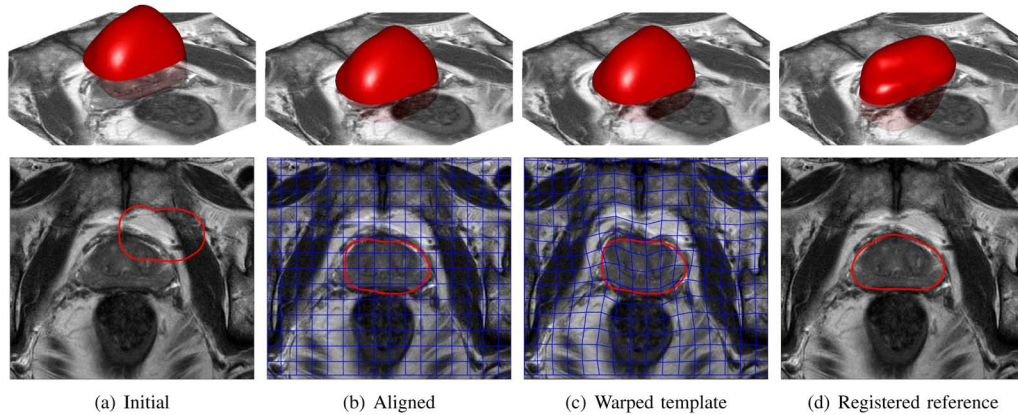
Registration process. (a) The initial *ex vivo* reference model (red) is overlaid on a slice of the *in vivo* T2-weighted template image. (b) Translated, rotated and scaled model after using the model-based alignment. (c) Warped template after using the proposed model-based elastic registration. (d) Registered model after applying the inverse map. A 3-D view (top row) of the model, and a 2-D cross-section (bottom row) are shown.
